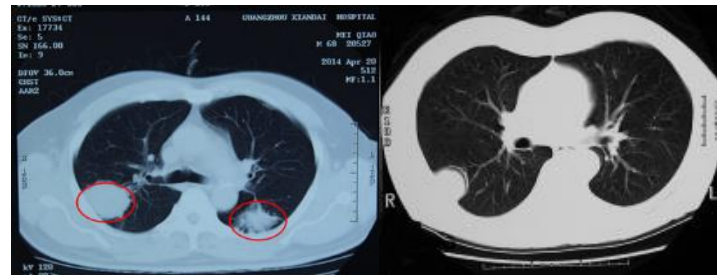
Left: CT Scan of Malignant Lung Cancer, Right: Benign Lung Cancer
